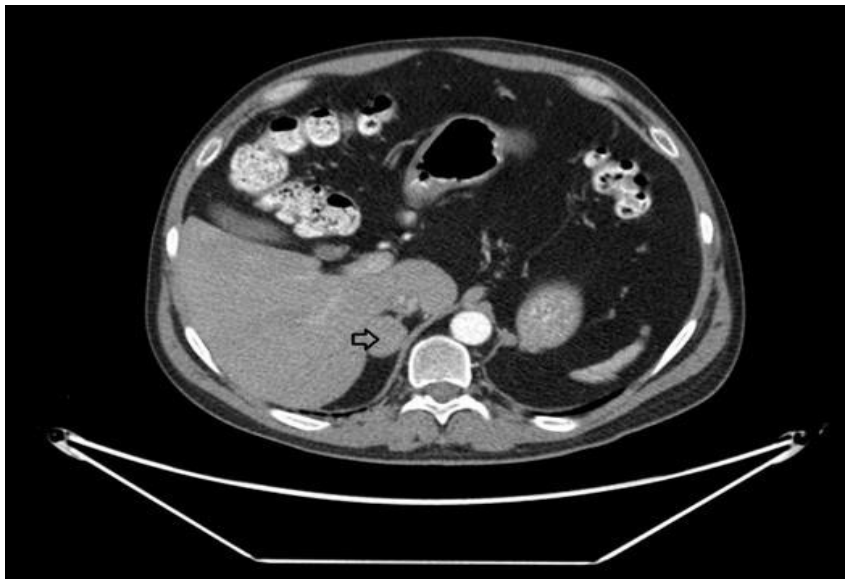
Axial cut of abdominal CT shows intermediate right adrenal nodule (arrow).
